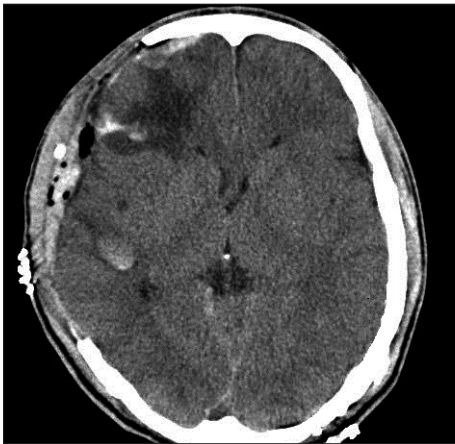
Postoperative computed tomography scan shows successful removal of subdural hematoma after decompressive craniectomy.
